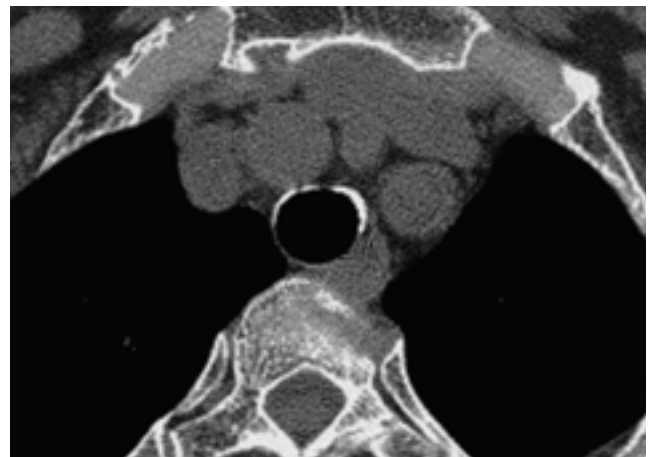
A 67-year-old woman with dense calcification of tracheal cartilage. High-resolution CT scan shows calcified cartilage. Posterior tracheal membrane appears thin and uncalcified.
